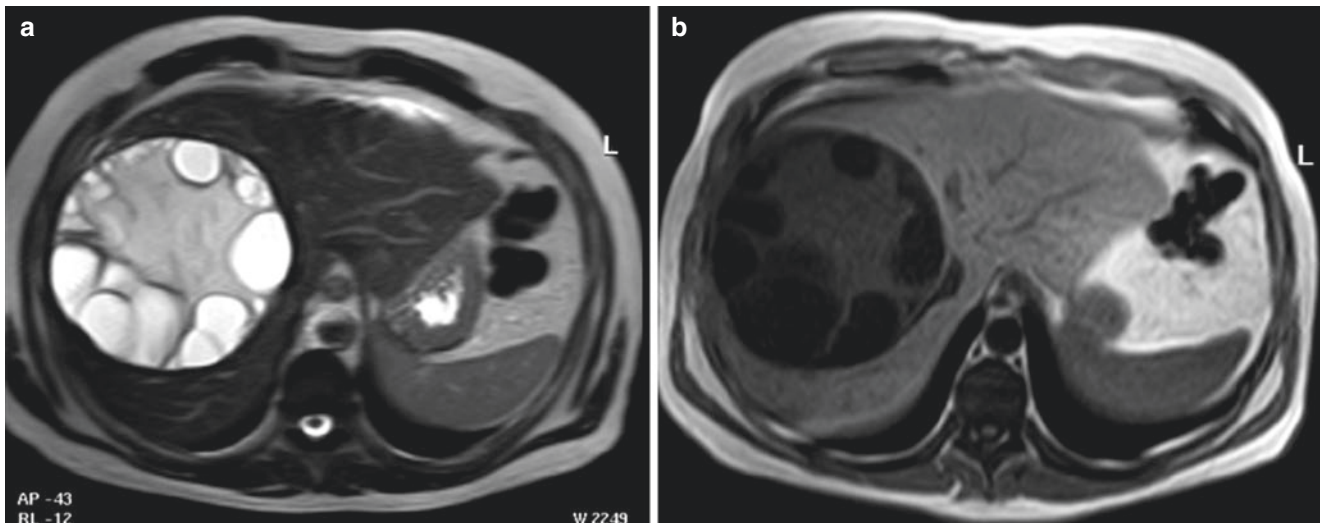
Echinococcus granulosus cyst. 28-year-old man with right upper quadrant pain. Axial (a) T2-weighted image demonstrates a large cystic mass in the right lobe of the liver which is surrounded by a hypointense rim and contains more hyperintense smaller cysts in its
